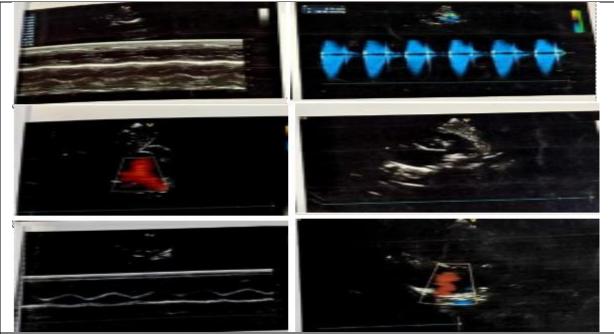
Doppler image across the pulmonary valve showing pulmonic valve PG 39.32 mmHg at 1 year of age
